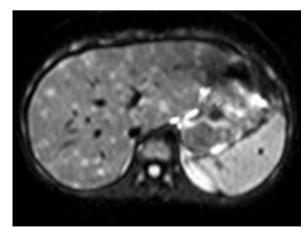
In case 2, magnetic resonance imaging showed multifocal small diffuse cystic liver lesions.
